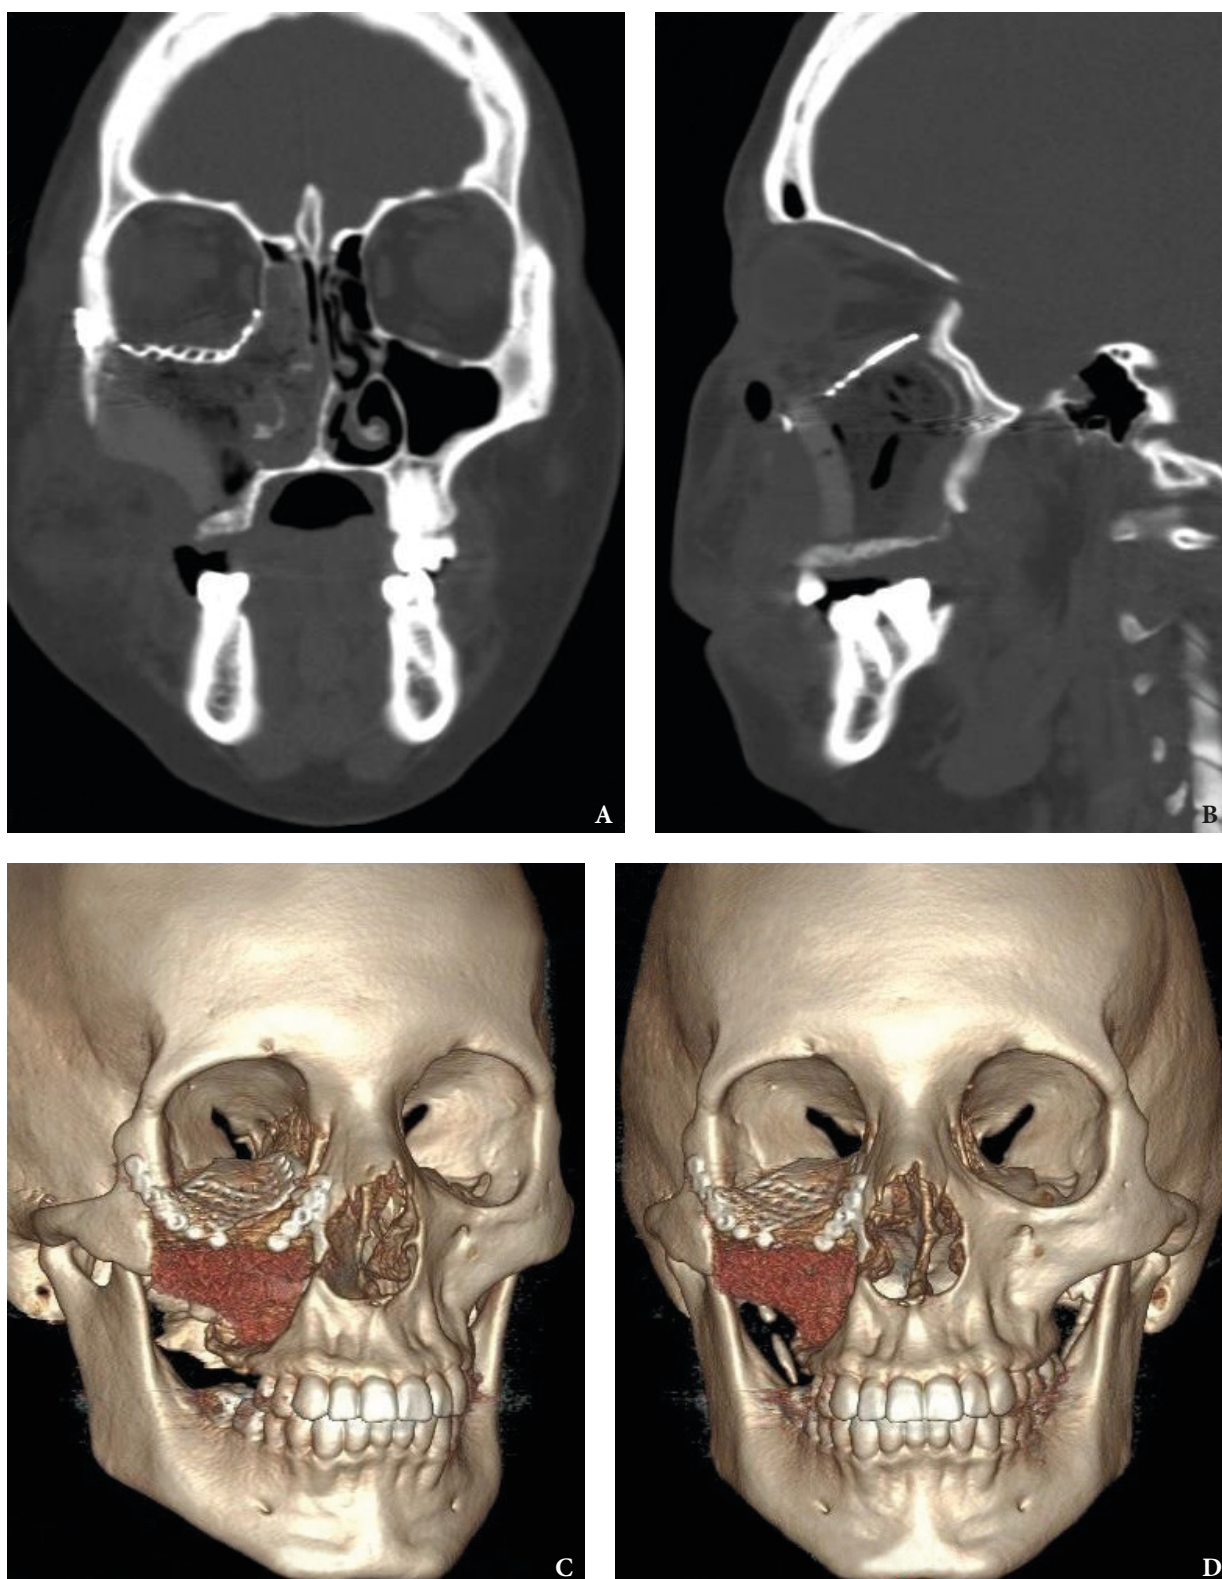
Postoperative CT scans: Coronal view (A), sagittal view (B), and 3-dimensional reconstruction (C, D).
